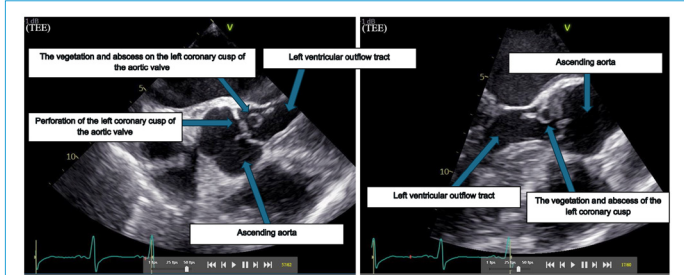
Transesophageal echocardiogram showing aortic valve vegetation and perforation on the left, and vegetation and abscess on the right.
